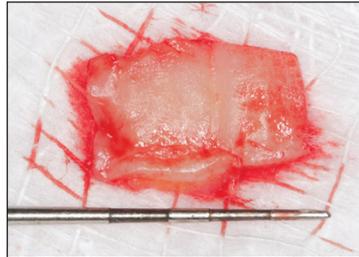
This technique consists of a single mesiodistal incision a few millimeters from the gingival margin, but with no vertical incisions. The CT graft is then harvested through the single slit. After the graft is harvested, the single incision can be sutured closed for primary closure, which results in a much lower risk for post-op bleeding complications. (Photo credit: Shmuel Stern, DDS, Miami.)
